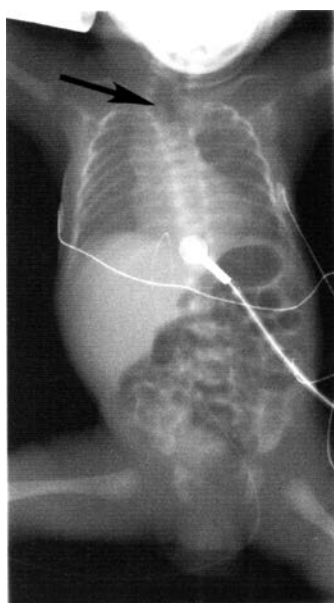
Esophageal atresia. Radiograph demonstrating air in the upper esophagus (arrow) and GI tract, consistent with esophageal atresia.
